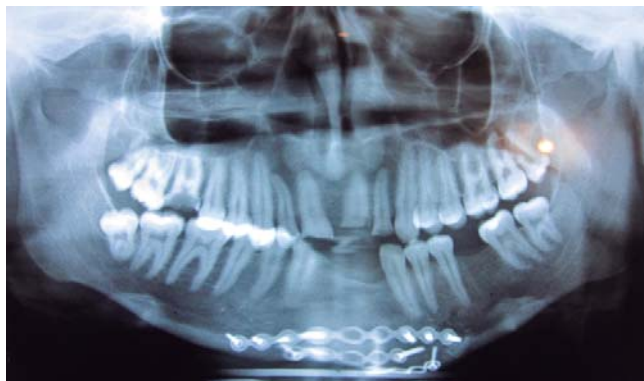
Initial panoramic radiograph. Screws and plates at the level of the mandibular marginal ridge.
